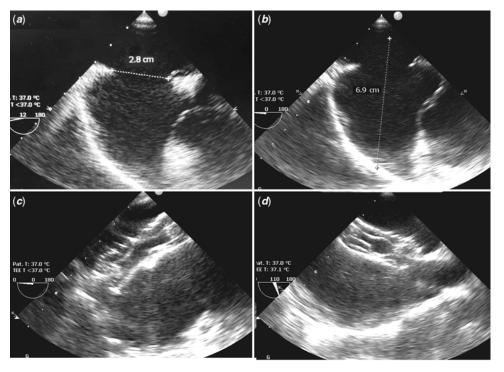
Intraoperative trans-oesophageal echocardiographic images during hybrid closure of a large atrial septal defect in a patient with interrupted inferior vena cava: (a) measurement of the atrial septal defect, (b) measurement between the atrial free wall to the mid-cavity of the left atrium to estimate the length of the sheath to be introduced, (c and d) following deployment of a 33-mm Occlutech septal occluder, with device in good position.
